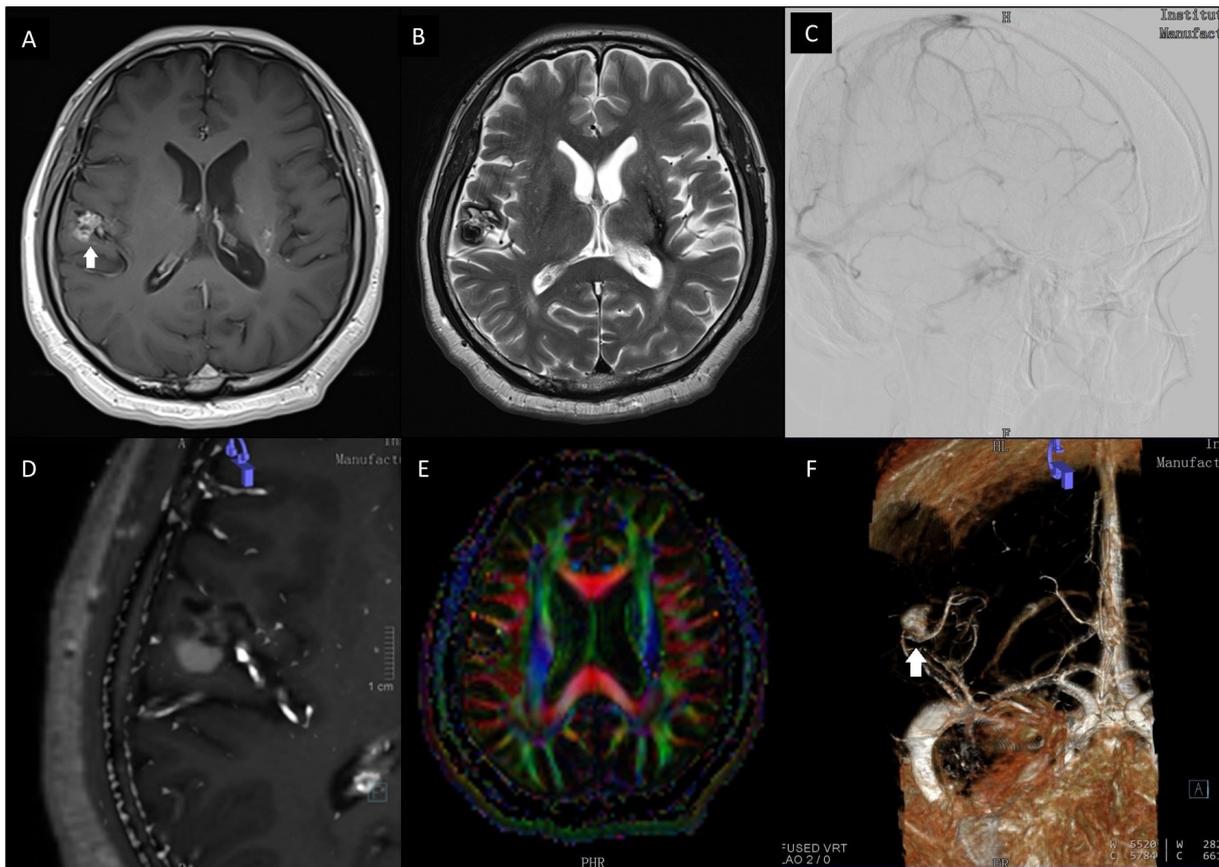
(A-B) MRI brain demonstrating the right parietal cavernoma (white arrow); (C) cerebral angiogram to assess the normal venous drainage; (D-E) intraoperative fusion of MRI with cerebral angiogram (D), DTI (E) and digital subtraction of brain parenchyma (F) for surgical planning and neuronavigation of cavernoma and developmental venous anomaly (white arrow).
